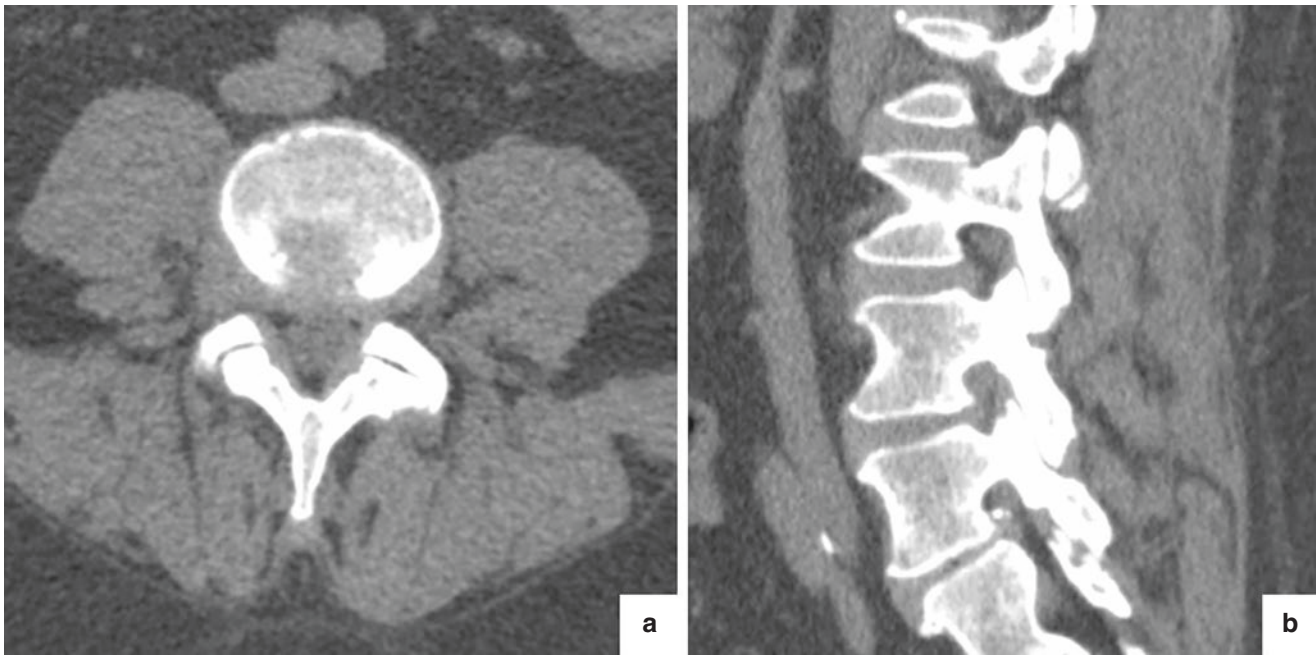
Thin slices of CT scan showing Right L4-L5 extraforaminal disk herniation: (a) axial section; (b) sagittal section
